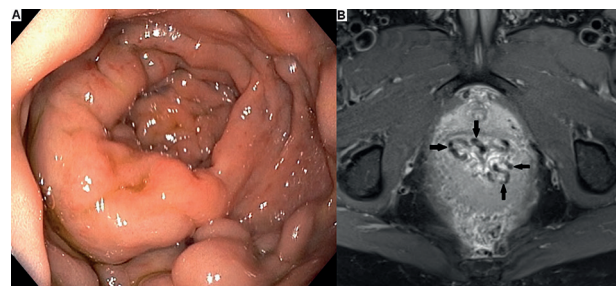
Congestive anorectal varices. (A) Colonoscopy showing enlarged tortuous rectal varices as submucosal elevations. (B) An axial T2-weighted fat-saturated MR image of the rectum showing a vast submucosal varicous network (arrows).
